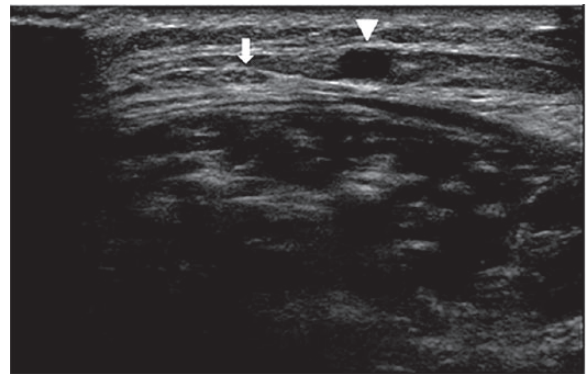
Ultrasonographic detection of the risk point: Sural nerve (arrow) is out of the saphenous compartment and 5 mm away from the small saphenous vein (arrow head).
